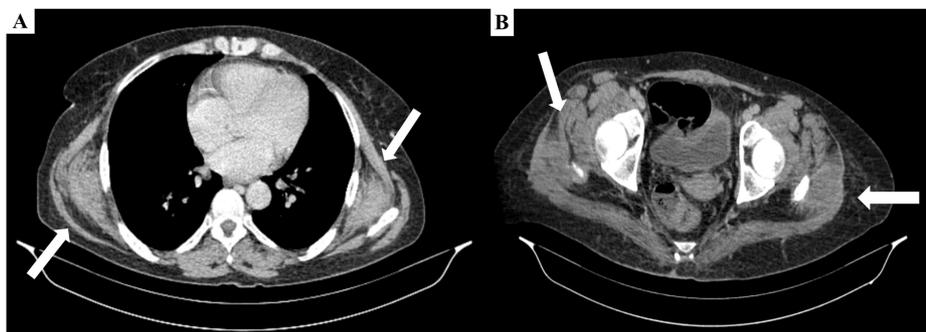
Contrast-enhanced CT (axial view) showing bilateral peri-scapular and gluteal elastofibromas on July 20, 2023
